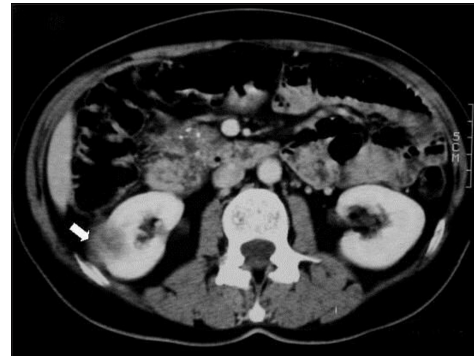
Computed tomography of abdomen demonstrating a kidney mass
